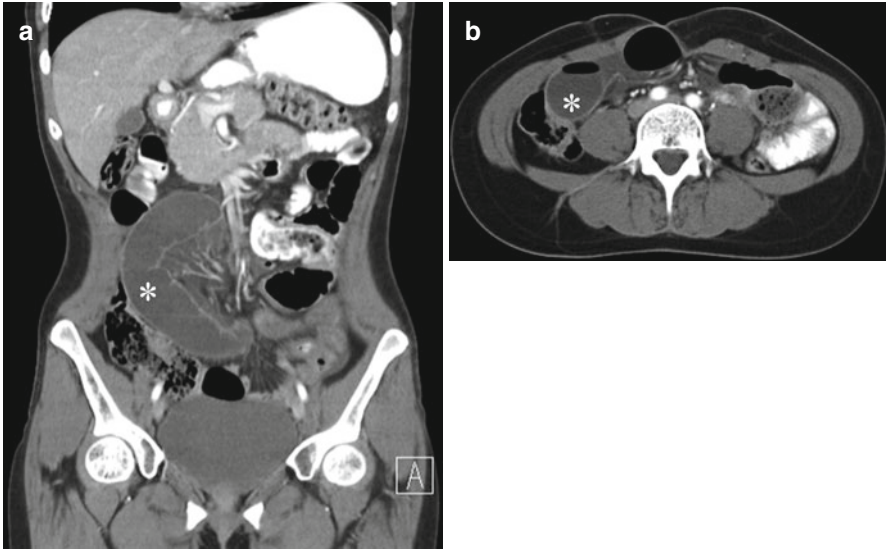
Axial (a) and coronal (b) CT images show fusiform tapering of a dilated bowel loop (*asterix*) with C-shaped configuration and a “beak” sign at the site of torsion
